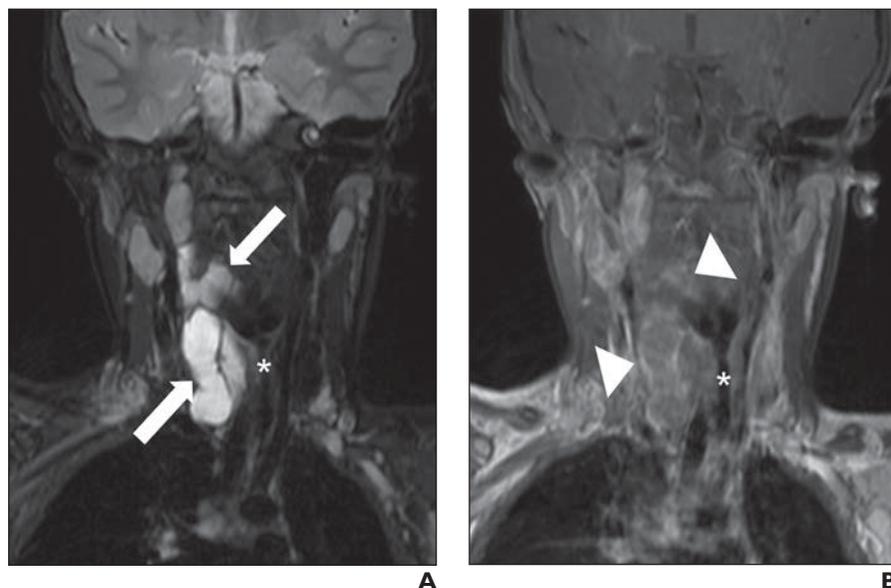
2-year-old boy with neck swelling from macrocytic lymphatic malformation. A and B, Coronal T2-weighted fat-saturated (A) and postcontrast T1-weighted fat-saturated (B) MR images of neck show hyperintense cystic spaces on T2-weighted imaging (arrows, A) crossing multiple tissue planes. Mild mass effect on adjacent esophagus (asterisks) is present. Septa show thin enhancement (arrowheads, B), but cystic cavities do not enhance.
